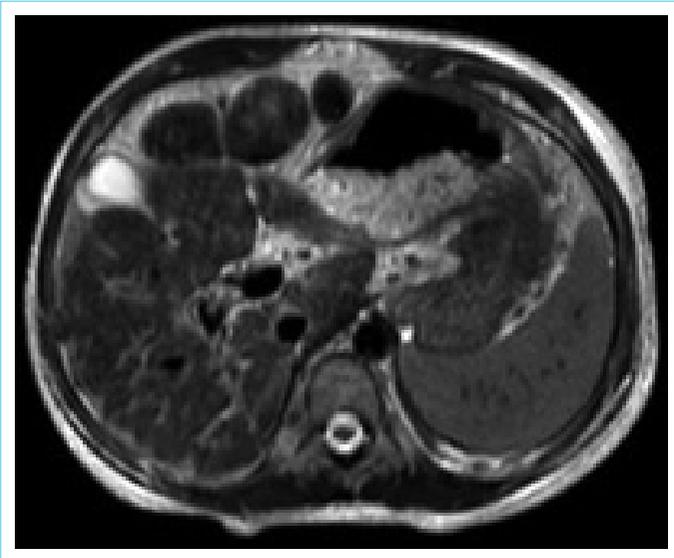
Heterogeneous liver parenchyma on magnetic resonance imaging
